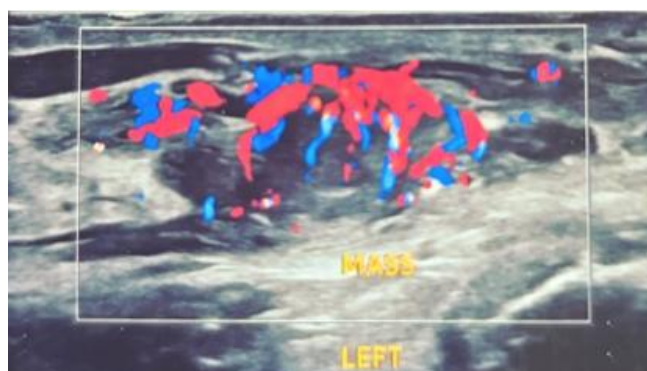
Ultrasound imaging showing increased vascularity in the intra-testicular mass
